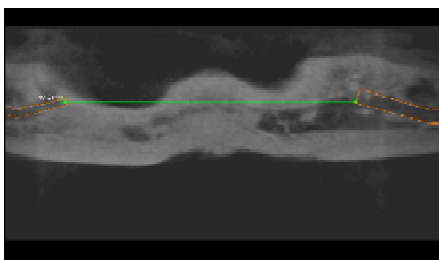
a, b, c: Height, width and interforamen distance of the bone assessed using CBCT.
